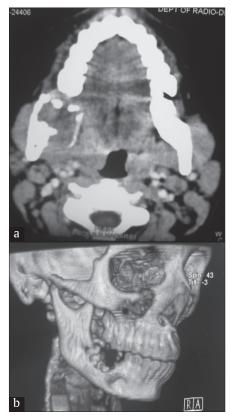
(a) Computed tomography shows an expansile lesion of the right mandible (b) Tomographic reconstruction image shows the extent of the lesion
